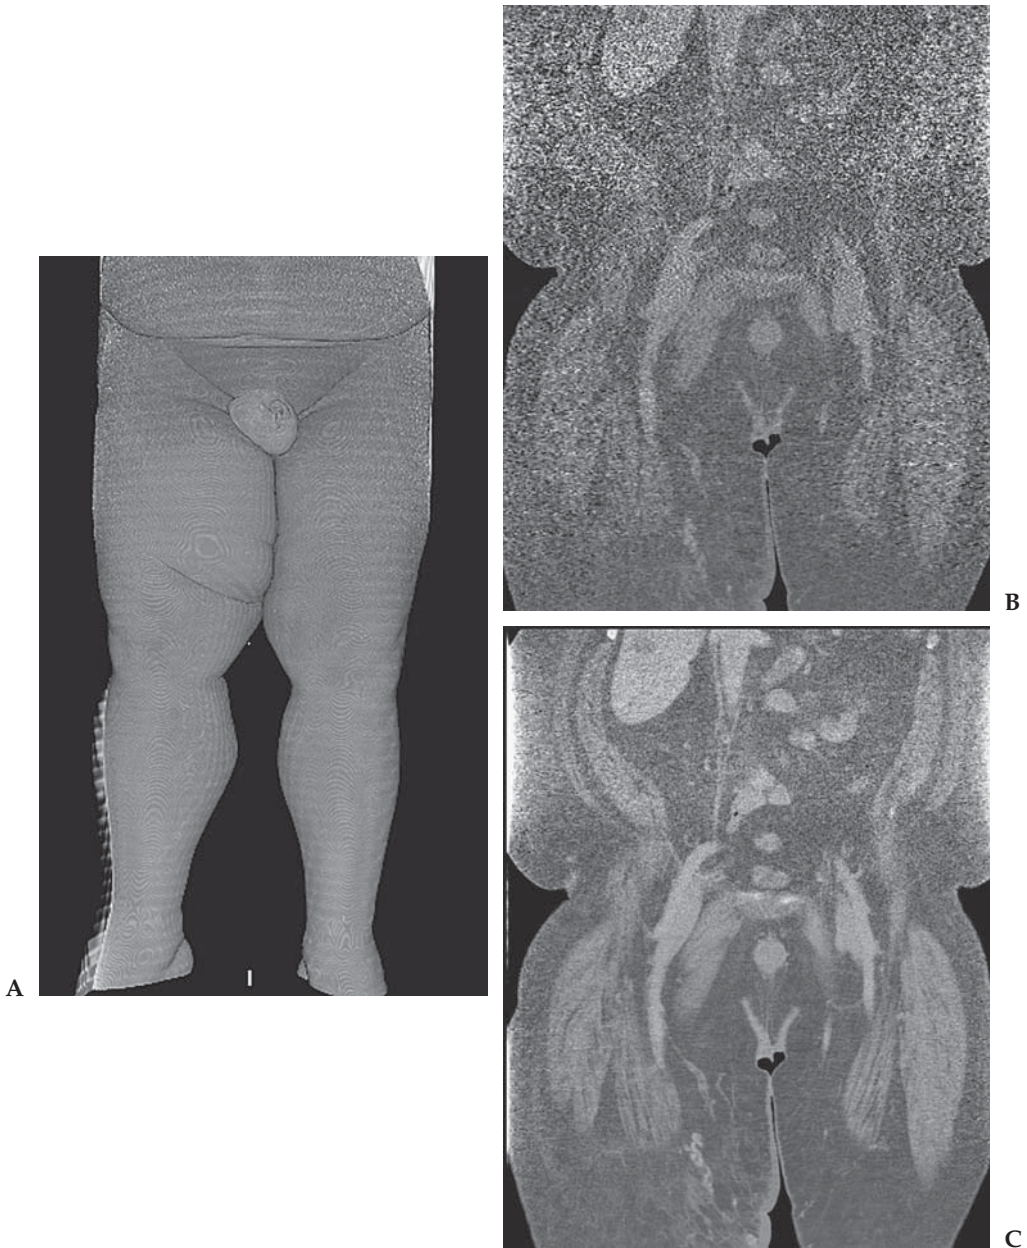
Lower extremity CT venogram in a 425-pound man. (A) SR image of the lower extremities in this morbidly obese man with leg swelling. Ultrasound could not adequately identify the veins to exclude deep vein thrombosis (DVT). The patient was also too big to fit in the magnet for an MR venogram. (B) Coronal 1-mm image from the CT venogram. Excessive image noise makes it difficult to evaluate the veins. (C) Coronal 5-mm image. Improved signal-to-noise ratio in the averaged image allows for adequate screening to exclude DVT in this man.
